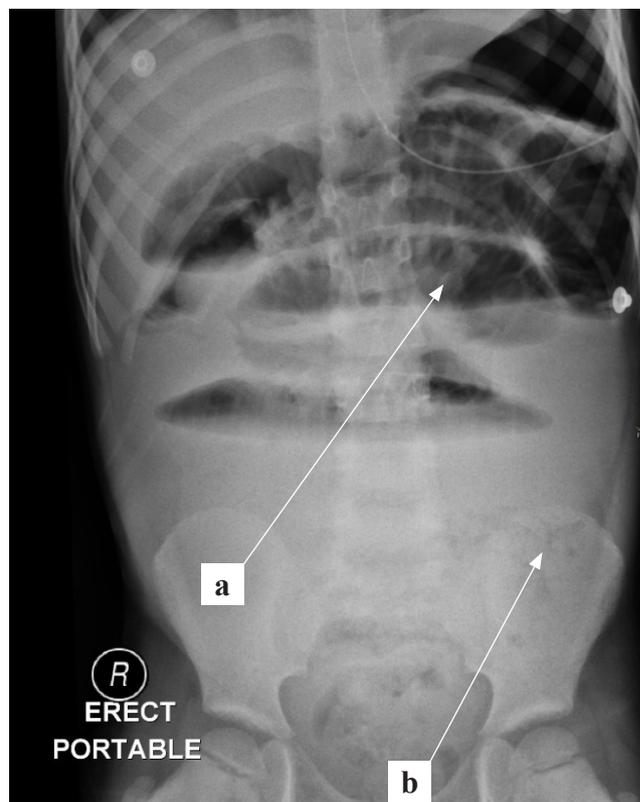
Abdominal X-ray demonstrating small bowel obstruction and an intestinal worm bolus – a) dilated small bowel loops with air-fluid levels, b) intestinal worm bolus
